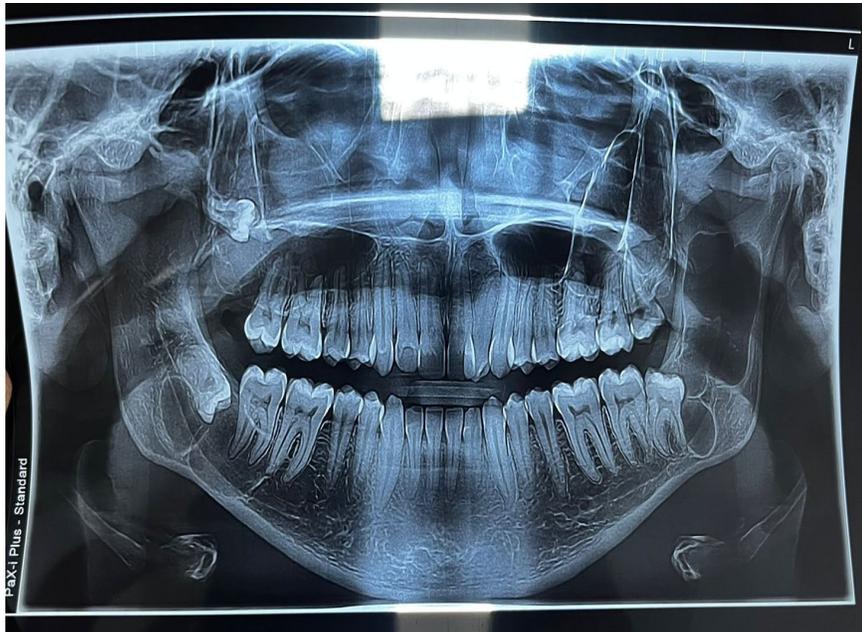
Radiographic appearance of multiple radiolucent lesions in the jaw for odontogenic keratocysts
